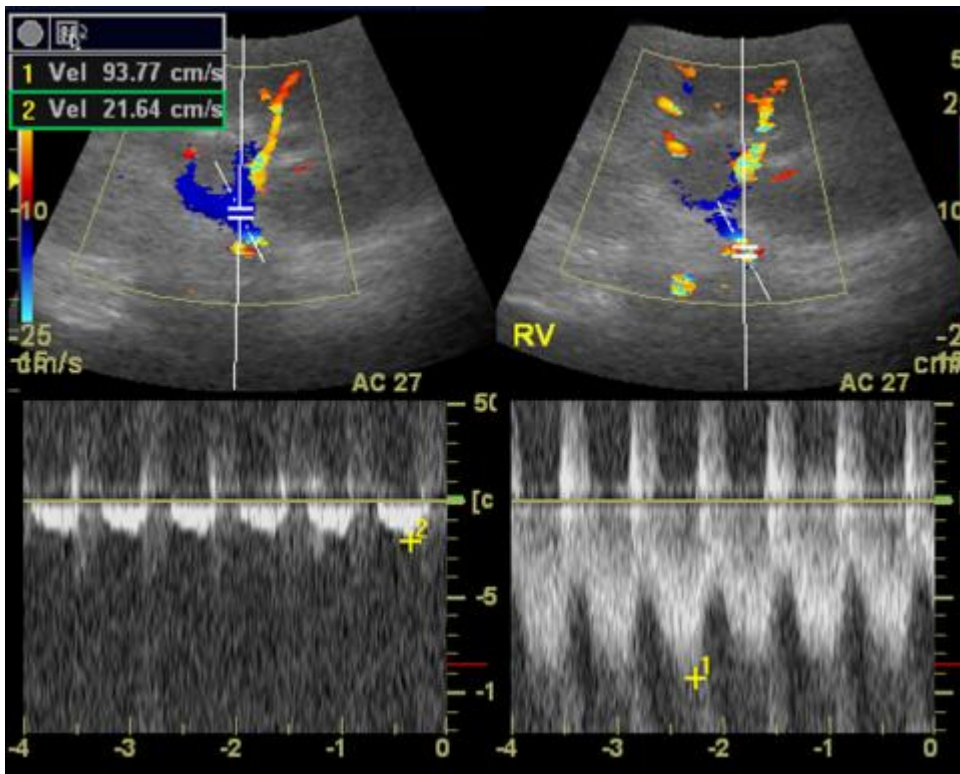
a Renal transplant venous stenosis. a) Spectral Doppler image demonstrates normal velocity in the renal vein at the level of the hilum. At the anastomosis, there is focal color aliasing and corresponding focally elevated velocity resulting in an approximately 4.3-fold velocity gradient.
